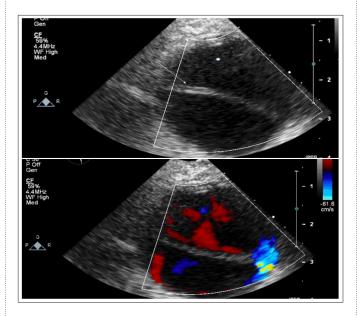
Shot axis view(SAX) of descending aorta on TOE. The arrow shows the intimal flap and the asterisk the false lumen. TOE, Transoesophangeal echocardiogram.
